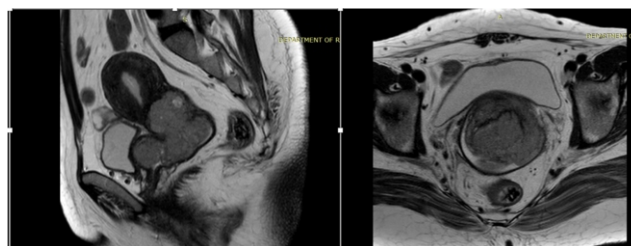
MRI in Carcinoma cervix- Sagittal T2 weighted (left) image shows lobulated hyperintense mass involving cervix with extension into lower uterine segment, upper third of vagina, bilateral fornices. Axial T2 image (right) shows loss of stromal hypointensity of cervix on left side with irregularity along the parametrium suggesting parametrial invasion
